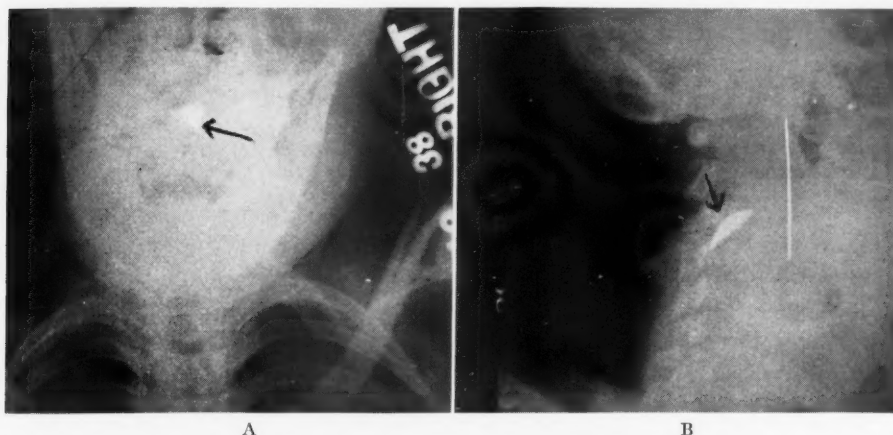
Roentgenograms showing (A) and (B) different aspects of the knife blade in the cervical cord.
